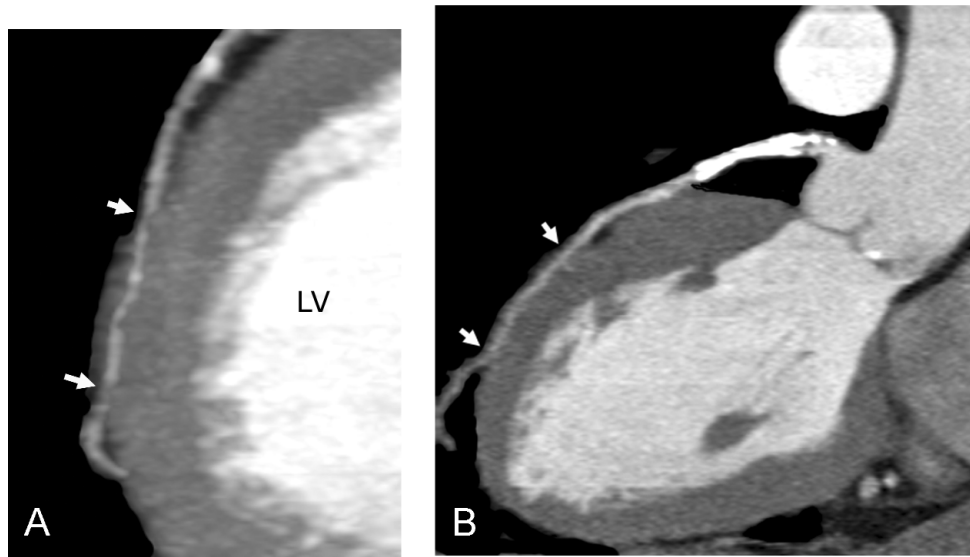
Myocardial bridging. A, myocardial bridging of the left anterior descending artery (LAD). White arrows denote the entrance and exit of the LAD from the myocardium. The length of the “tunnelling” can be measured with multislice computed tomography (MSCT). B, Myocardial “attachment” of the LAD. This LAD is attached to the myocardium but is not intramyocardial. Nonetheless, severe difficulties in suturing the anastomosis of the LAD had occurred intraoperatively in this 49-year-old man and, finally, the diagonal branch had to be taken for revascularization.
